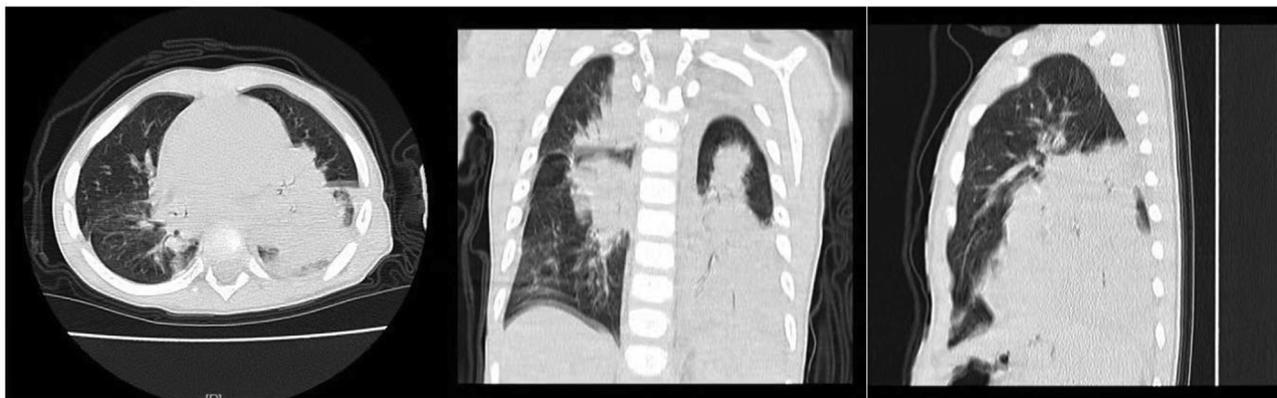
High-resolution CT scan of the chest revealing areas of extensive consolidation mainly involved the left lower lobe and right upper lobe with a slight pleural in a 12-months-old child with severe adenovirus pneumonia.
